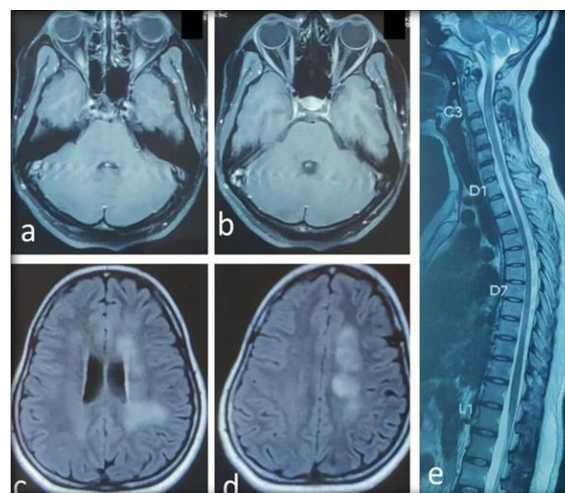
MRI orbit T1 contrast images showing bilateral perineural optic nerve sheath enhancement (a) and (b) increased signal in both optic nerves. (c) and (d) shows large fluffy cortical and subcortical hyperintensities. Cervical cord showing multiple short segment hyperintensities (e) seen in MOGAD cases.
